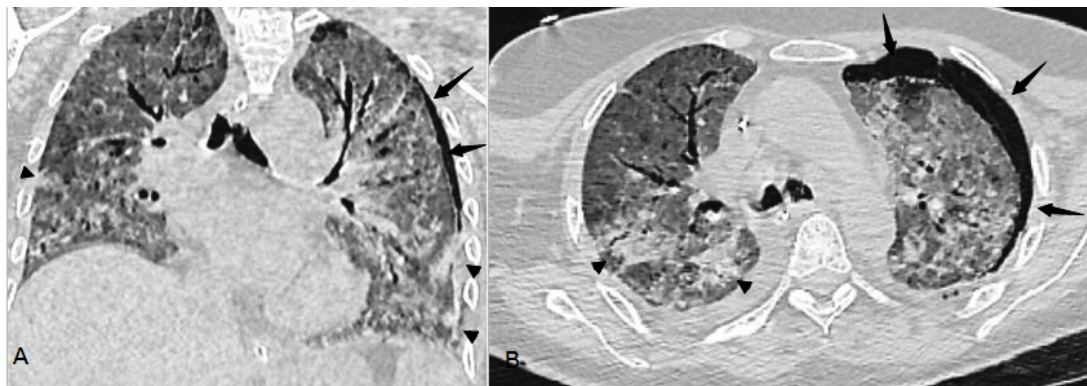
Axial and coronal unenhanced chest computed tomography. Pneumothorax (arrows), multiple ground-glass opacities and consolidations (arrowheads), in both lung fields.
